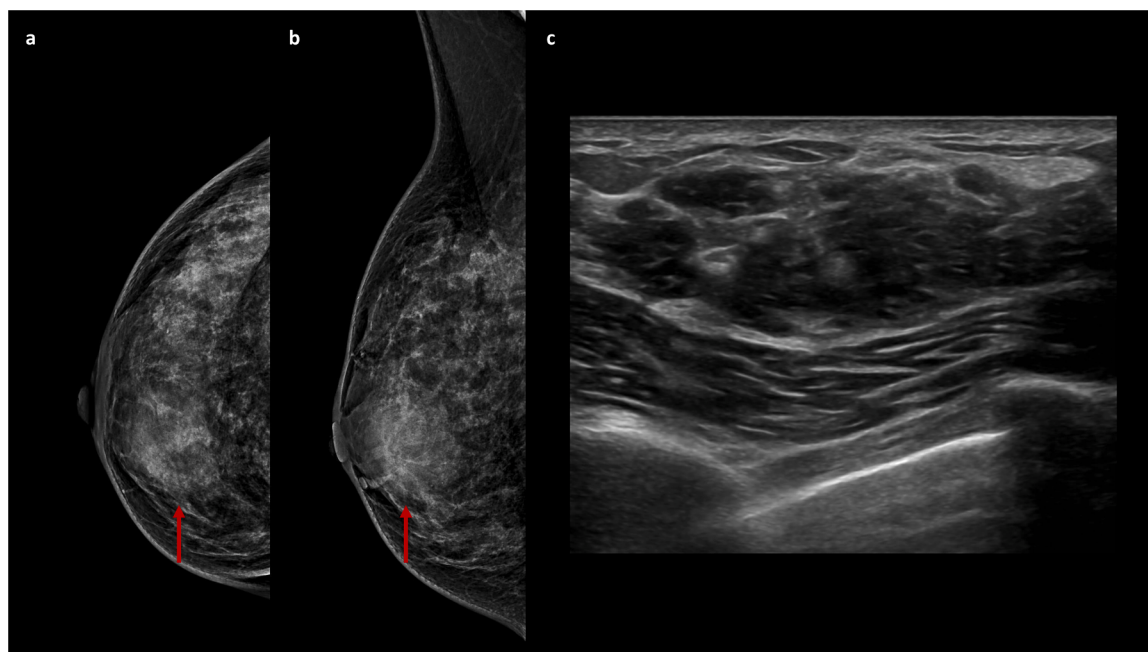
Representative case of non-calcified DCIS. (a) Cranio-caudal and (b) medio-lateral oblique mammographic views of the right breast show a subtle fuzzy opacity in the retro-areolar region (red arrows). (c) Corresponding ultrasound image reveals an ill-defined, inhomogeneous hypoechoic area consistent with the mammographic finding.
